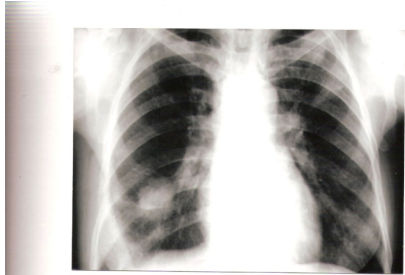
Photograph of X-Ray Chest (P-A view) showing rounded mass in right lower lobe in a patient of adenocarcinoma lung.
